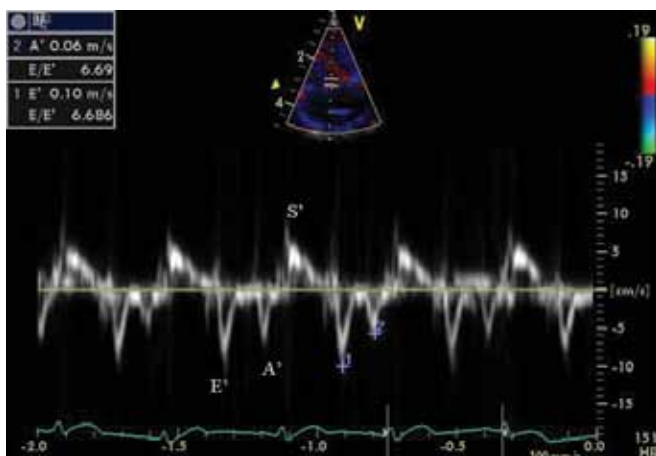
Apical 4-chamber view (top) with TDI obtained at the septal wall (bottom). Peak systolic (S'), peak early diastolic (E'), and peak late diastolic (A') velocities are noted.
